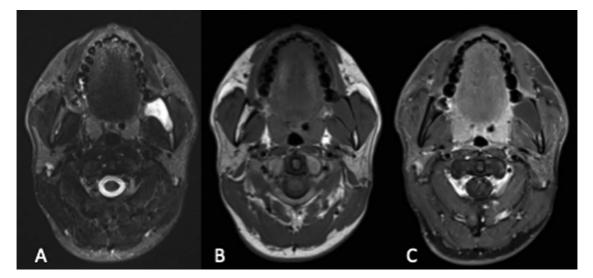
(A) Short tau inversion recovery (STIR) image. (B) T1-weighted image. (C) Contrast-enhanced T1-weighted image of the same case (odontogenic keratocyst) in axial slices.
